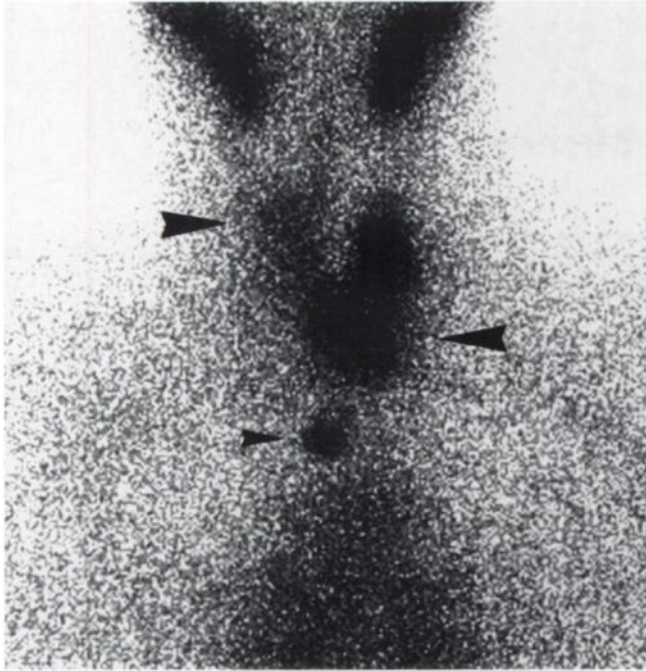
Technetium-99m-pertechnetate scintigraphy (anterior view) depicts no significant uptake in the right lobe; there is faint visualization of the upper pole of this lobe (arrow). Reduced activity in the nodule located in the inferior pole of the left lobe (arrow). A radioactive marker is located in the jugular region (small arrow).
